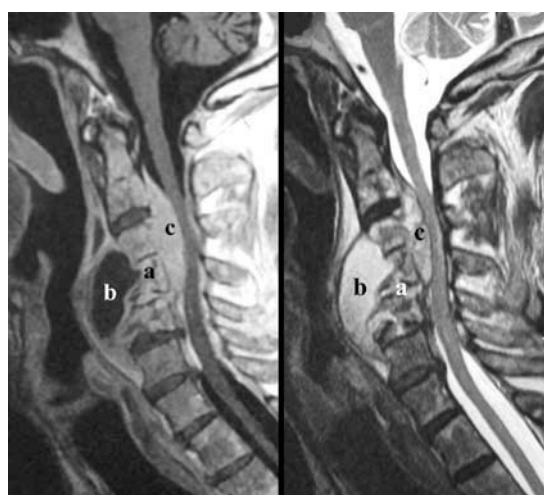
T1 (left) and T2 (right) sagittal cervical MRI with intravenous contrast. Destruction of the C3–C5 vertebral bodies (a), substituted by an abscess that extends along the prevertebral space (b) and epidural space (c), producing medullar compression by obliteration of the spinal canal.
